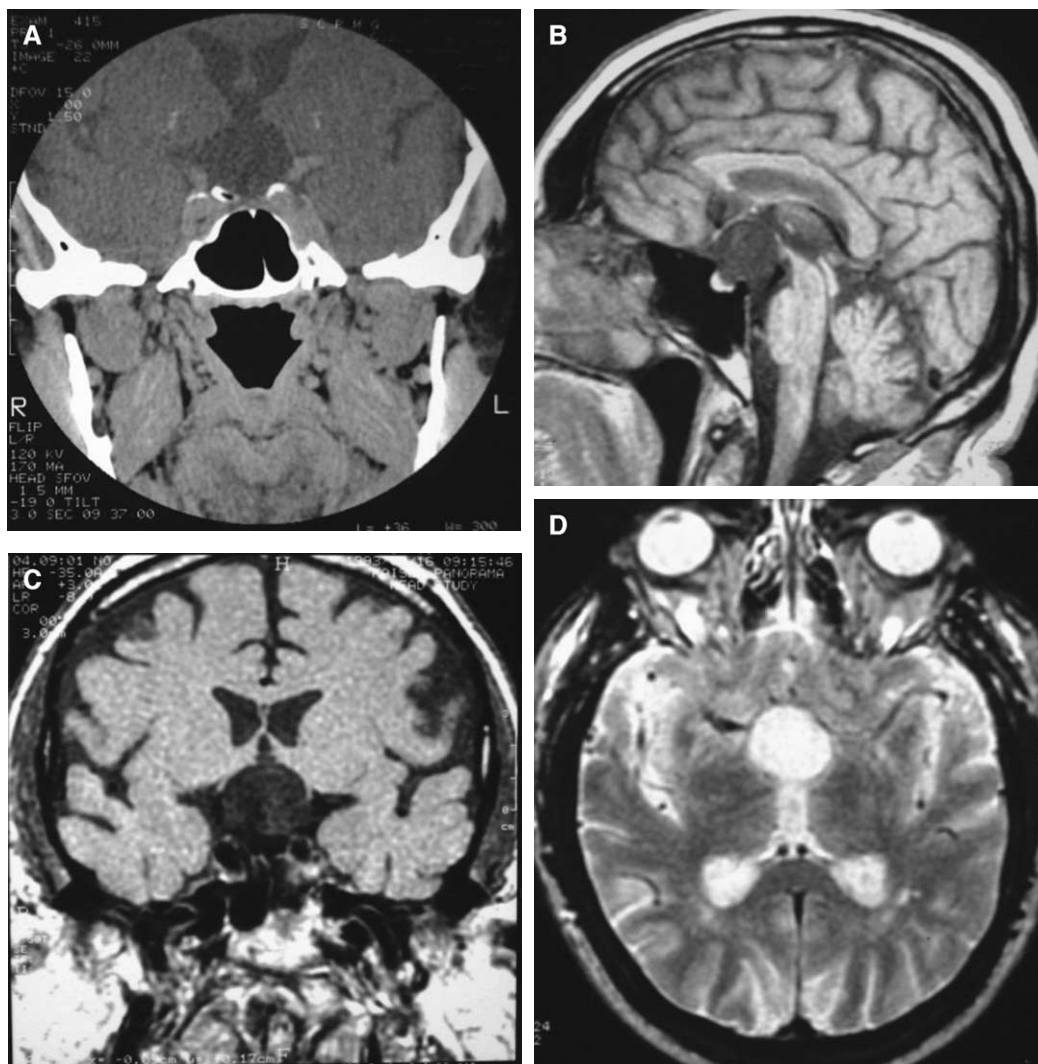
Epidermoid. (A) Coronal postcontrast CT scan demonstrates a cystic suprasellar mass with no evidence of enhancement. (B) Sagittal T1-weighted image demonstrates a cystic suprasellar mass with compression of the optic chiasm. The mass shows similar signal intensity as cerebrospinal fluid (CSF). (C) Coronal T1-weighted image demonstrates suprasellar cystic mass with compression of the optic chiasm. (D) Axial T2-weighted image reveals the cystic mass with similar signal intensity to CSF.
